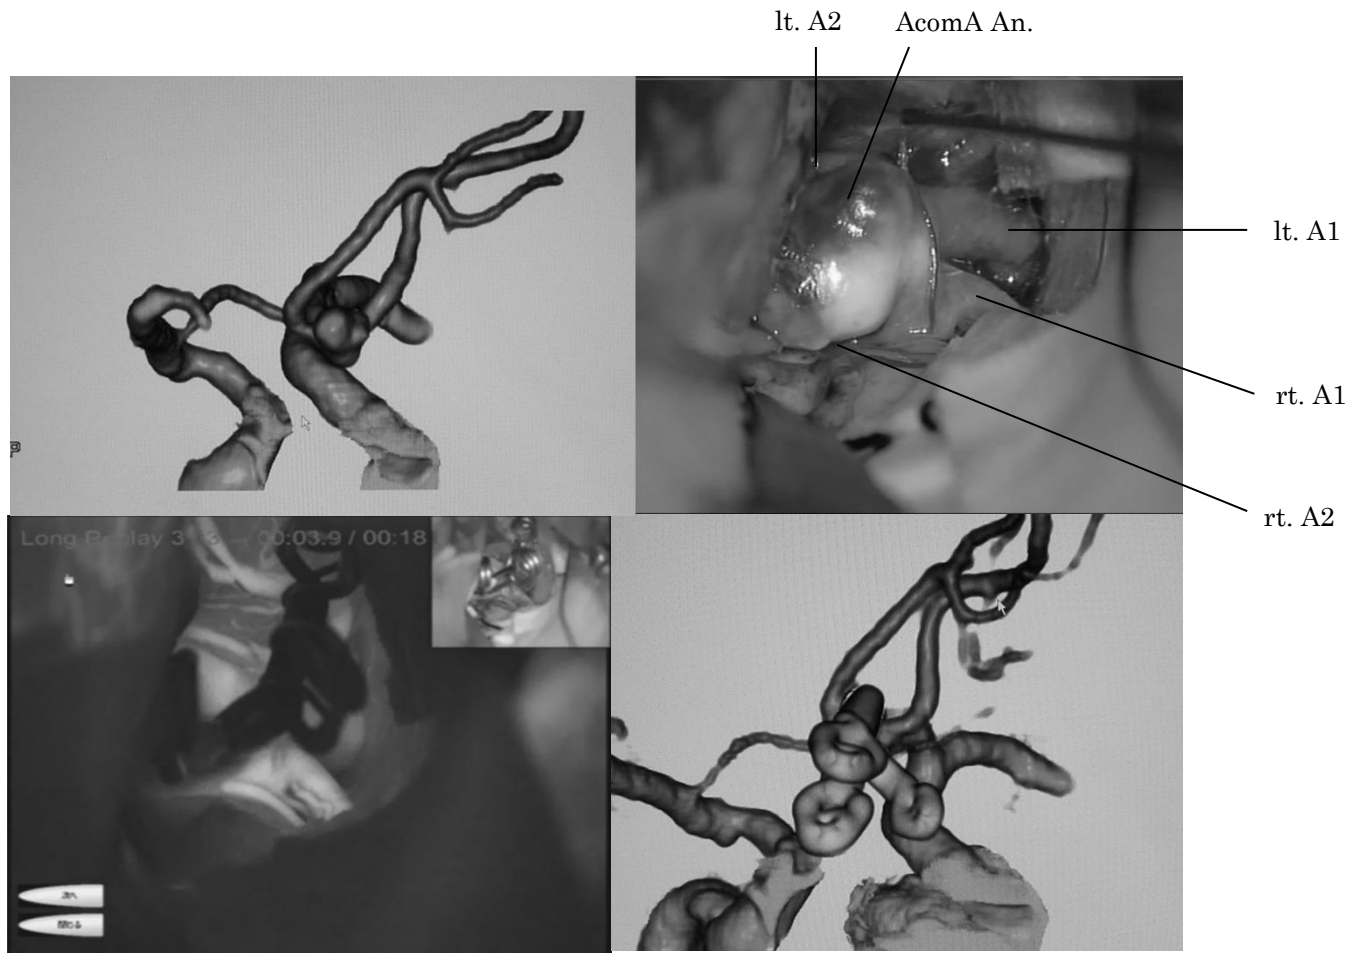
A 74-year-old man with an enlarging AcomA An. CTA showed that an AcomA complex was open to right side (A). Rt. PA was performed. Intraoperative findings clearly revealed an AcomA complex and An.(B), complete obliteration of the An. and preservation of each branches (C), confirmed by postoperative CTA (D).
